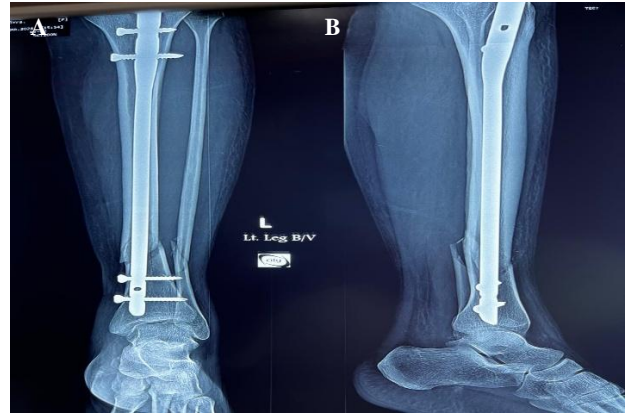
(A and B): Post-operative X-ray showing internal fixation.
